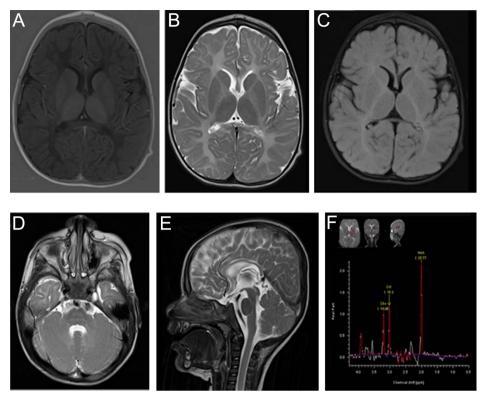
MRI images showing diffuse altered signal intensity change hypointense on T1 (A), hyperintense on T2 (B), FLARE in the white matter of both the cerebral hemispheres (C), both dentate nuclei and BILATERAL (B/L) cerebellar hemispheric white matter (D). Subtle symmetrical T2/Fluid-attenuated inversion recovery (FLAIR) hyperintensity is also seen along both the corticospinal tract (CST) in the pons, median pontine raphe and B/L CTT (D). Thinning of the corpus callosum with (F) MRS showing increased N-acetylaspartate (NAA) peak (E). CTT, central tegmental tract; MRI, magnetic resonance imaging.
